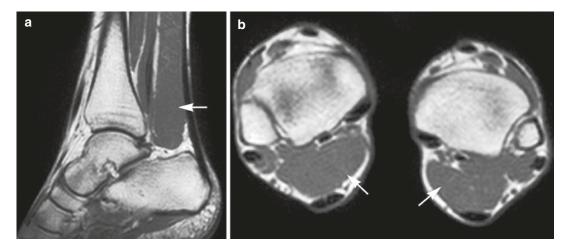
Accessory soleus muscle in an adult man: (a) sagittal spin echo T1-weighted MR image; (b) axial spin echo T1-weighted MR image. There is a muscle belly
